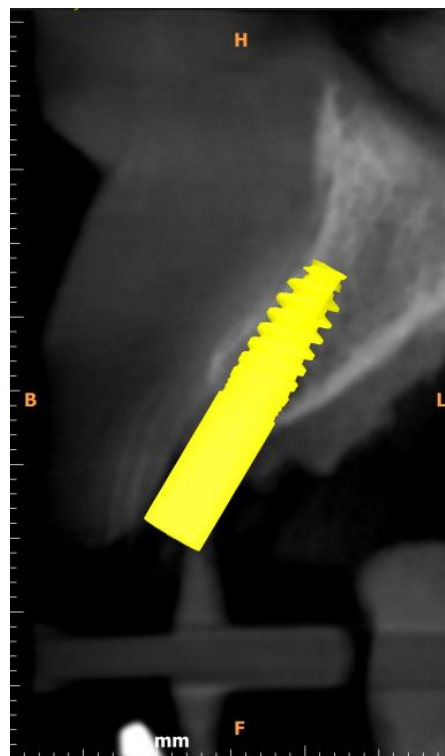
CBCT sagittal view of 12 socket revealed bone remodelling, and that (using an implant blank - 4.3 x 11.5mm NobelActive® implant blank) particulate at the labial aspect would likely be necessary at implant fixture placement.
